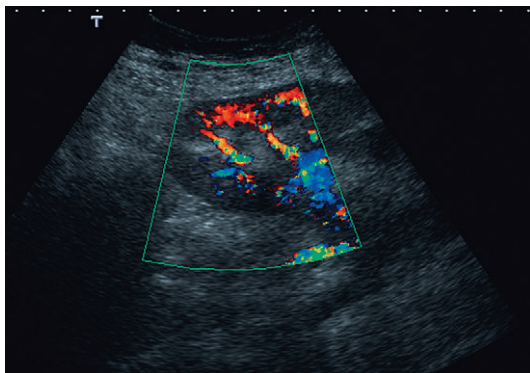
Colour flow Doppler in the left posterior oblique position demonstrating the origin of both renal arteries.
